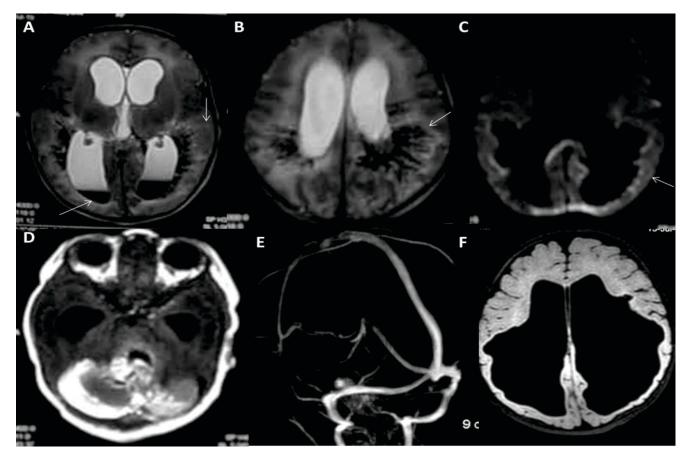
Medullary venous congestion and periventricular leukomalacia due to presumable thrombotic angiopathy of deep venous system. Multifocal lesions suspected in view of cerebellar bleeds. A &B: T2 weighted images showing hydrocephalus with intra-ventricular bleed with layering in lateral ventricles (arrow A). Radiating periventricular linear signal presumably due to congested medullary veins (arrows B and C). C: Diffusion weighted image showing periependymal diffusion restriction indicating deep white matter ischemic damage (arrow). D: T1 weighted images showing haemorrhages in posterior fossa possibly secondary to deep venous thrombosis or multifocal thrombotic lesions. E: MR venography showing patent major venous sinuses . F: FLAIR (Follow up) image showing further dilatation of lateral ventricles due to destruction of ischemic white matter
